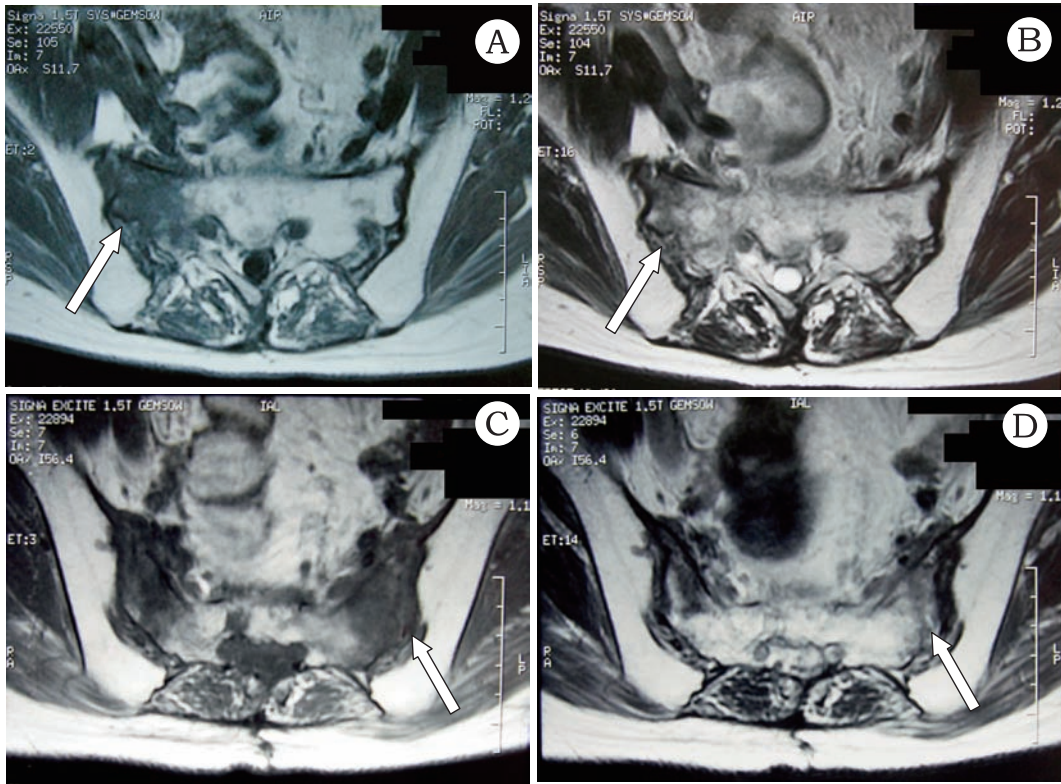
Axial views of MRI of the sacrum 7 months after the completion of radiation therapy demonstrate a new tumor-like lesion in the upper right segment of the sacrum (arrows). The lesion shows isointense signal on T1-WI (5A) and hyperintense signal on T2-WI (5B). Axial views of MRI of the sacrum, 1 month after the new tumor-like lesion developed, demonstrate another tumor-like lesion in the left segment of the sacrum (arrows). This new lesion also shows isointense signal on T1-WI (5C) and hyperintense signal on T2-WI (5D).
